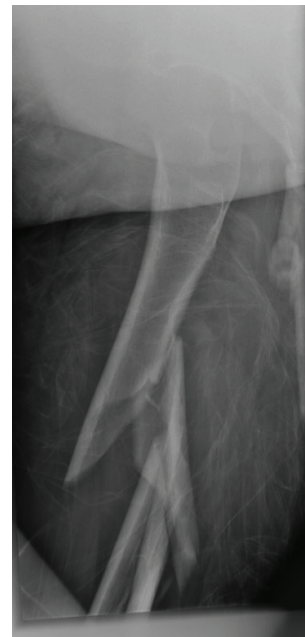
Anteroposterior (AP) and Lateral radiograph post-failed fixation revealing a comminuted femoral fracture.
